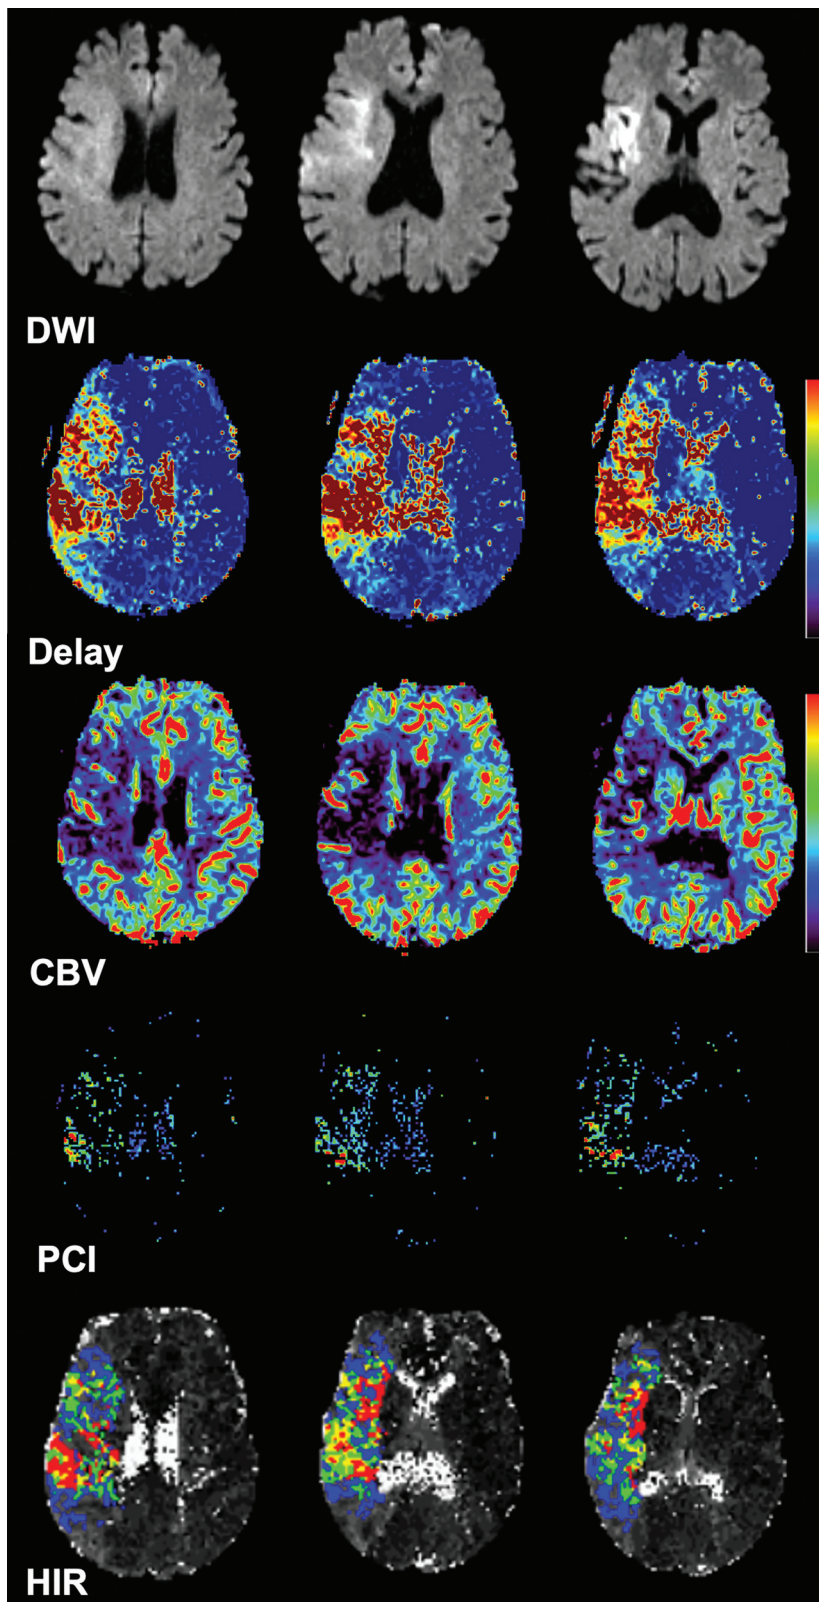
Example of discordance between the PCI and HIR in a patient with insufficient angiographic collaterals. Adult patient with left hemiparesis who underwent MR imaging approximately 1.3 hours after symptom onset. The patient has a right M1 occlusion (not shown). Aligned axial DWI, delay, CBV, PCI, and HIR maps from MR perfusion are shown. There is an ischemic core involving the right operculum, insula, and basal ganglia. There is low CBV in the region involved with PCI values estimated at 38, suggestive of insufficient collaterals. The estimated HIR is 0.30, suggestive of sufficient collaterals. Baseline catheter angiography (not shown) revealed poor collaterals (ASITN 1).
